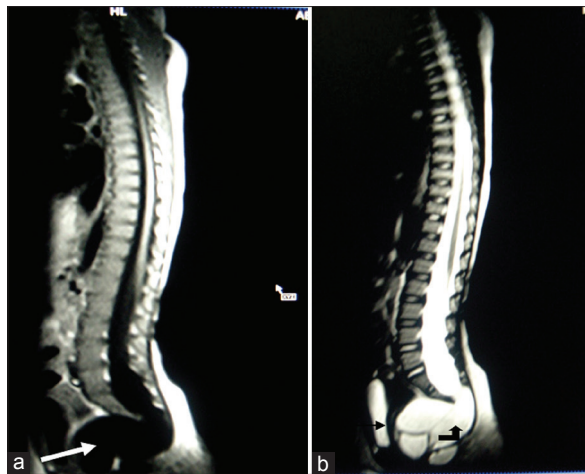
Sagittal views of lumbo sacral magnetic resonance imaging. T1-weighted (a) and T2-weighted (b) an anterior sacral cystic mass which is a meningocele (white arrow). It is continuous superiorly (black arrow) with a widened thecal canal, and there is compression of the urinary bladder (black arrowhead)
